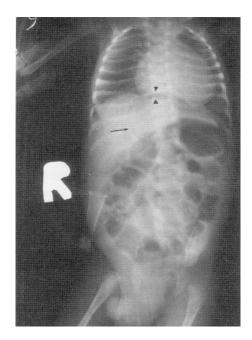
Plain x-ray babygram, supine position, shows minimal free air " anterosuperior oval" which was missed mitially.
